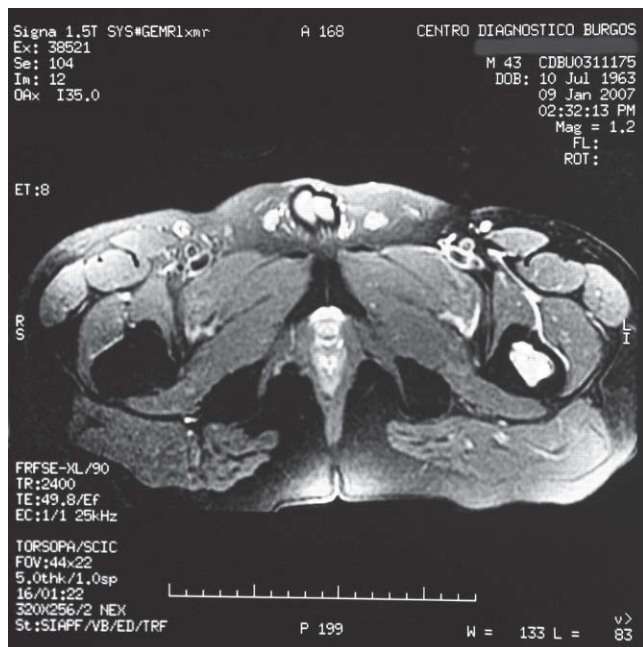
Magnetic resonance image in which a lesion is appreciated in the proximal metaphysis of the left femur with hyperintense signal in the T2 sequence, with well-defined border and that respects the cortex.
